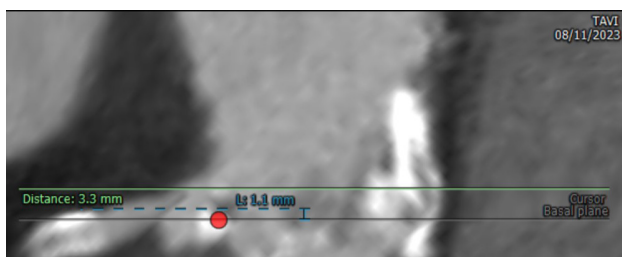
CT Aorta for TAVI showing low coronary heights
